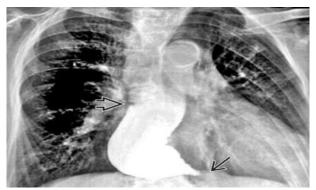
X-Rays of the oesophagus with achalasia.
